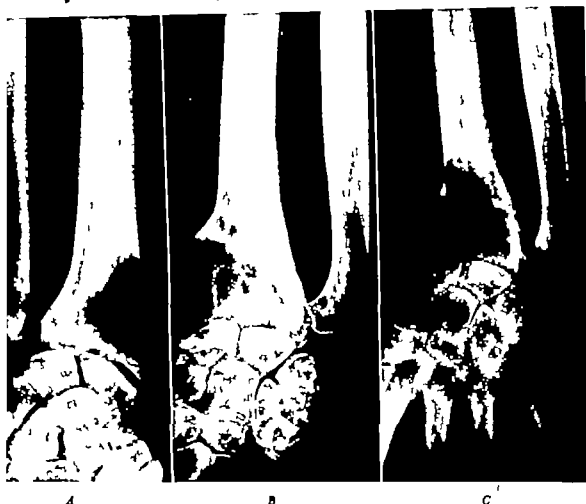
A series of roentgenograms showing progression of a giant-cell tumor situated in the lower end of a radius, another frequent site of development. *A* Initial film showing eccentric position of the tumor its uniformly rarefied appearance as well as thinning and slight expansion of the overlying cortex which is still intact. *B* The appearance of the tumor 7 months later. *C* Its appearance prior to surgical treatment (11 months after the initial film). The tumor now occupies the entire width of the radius and has extended in places through the eroded cortex. The carpal bones show pronounced disuse atrophy. The importance of early diagnosis and prompt effective treatment cannot be too strongly emphasized.
